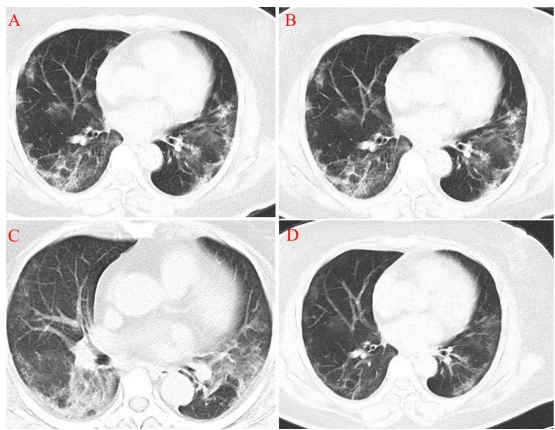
Chest CT images from a 58-year female. (A) Day 9 after symptom onset: Bilateral multifocal ground-glass opacities and partial consolidations, with local thickening and adhesions of bilateral pleura; (B) Day 17: the lesions had increased in extent and the density, with bilateral pleura thickening; (C) Day 23: the lesions increased in extent and the density and became heterogeneous, with air bronchograms inside (red arrow); (D) Day 30: the lesions continued to decrease in extent and the density. The patient was ready for discharge from hospital after the final scan.
